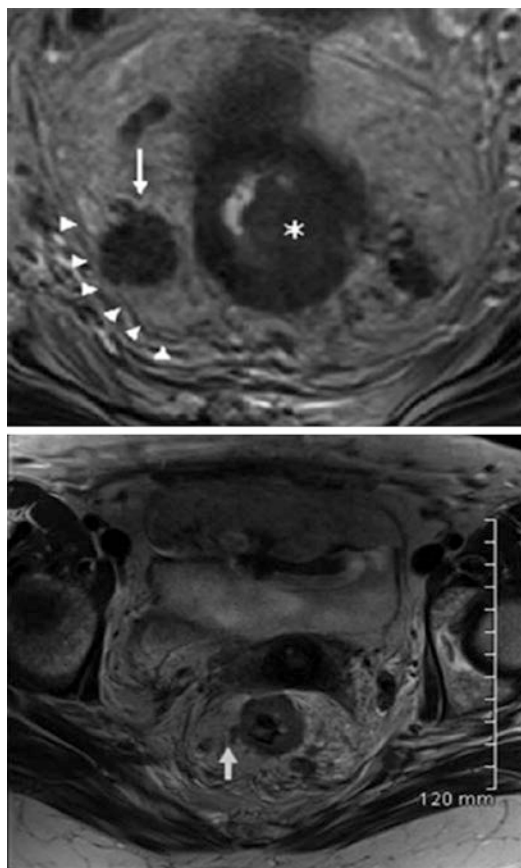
Magnetic resonance image of locally advanced rectal cancer demonstrating the circumferential resection margin. (With permission © Springer)
